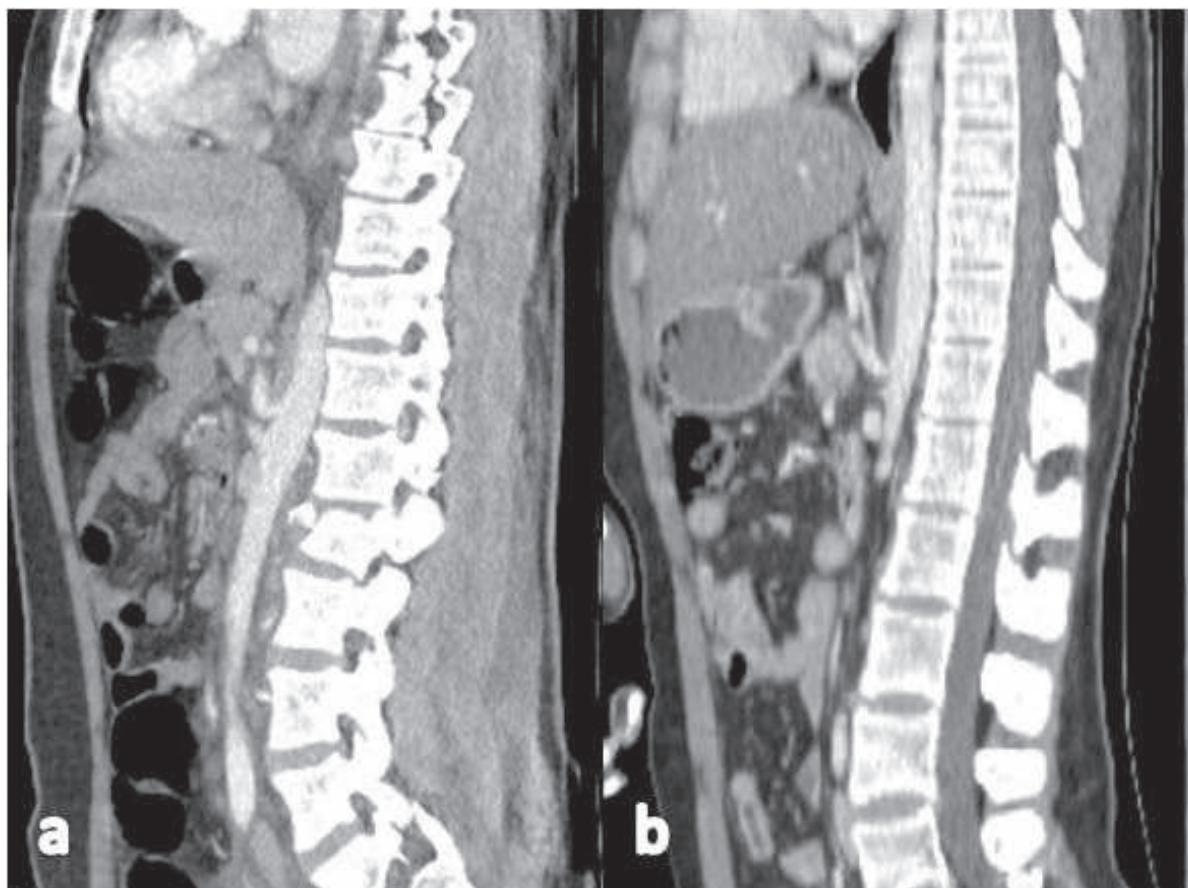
Sagittal contrast-enhanced abdominal CT images. a. Mild stenosis at the origin of the celiac trunk (<50%); b. Severe stenosis (>50%).
